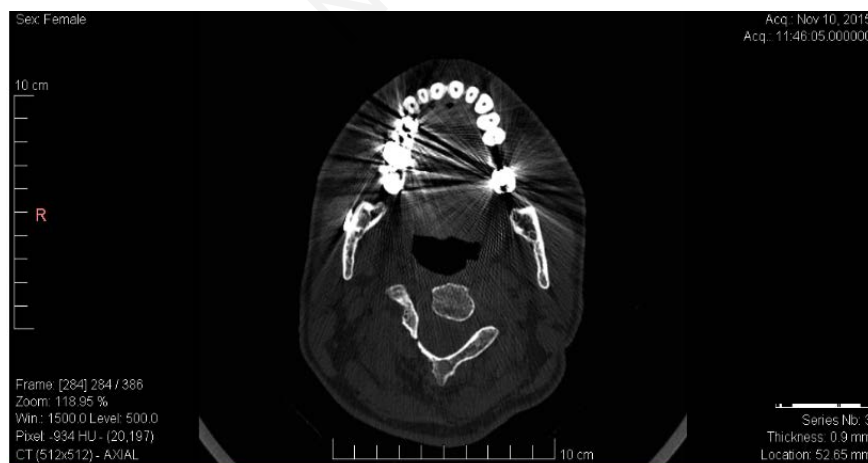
Coronal computed tomography scan 18 months after the operation showing no local recurrence.
